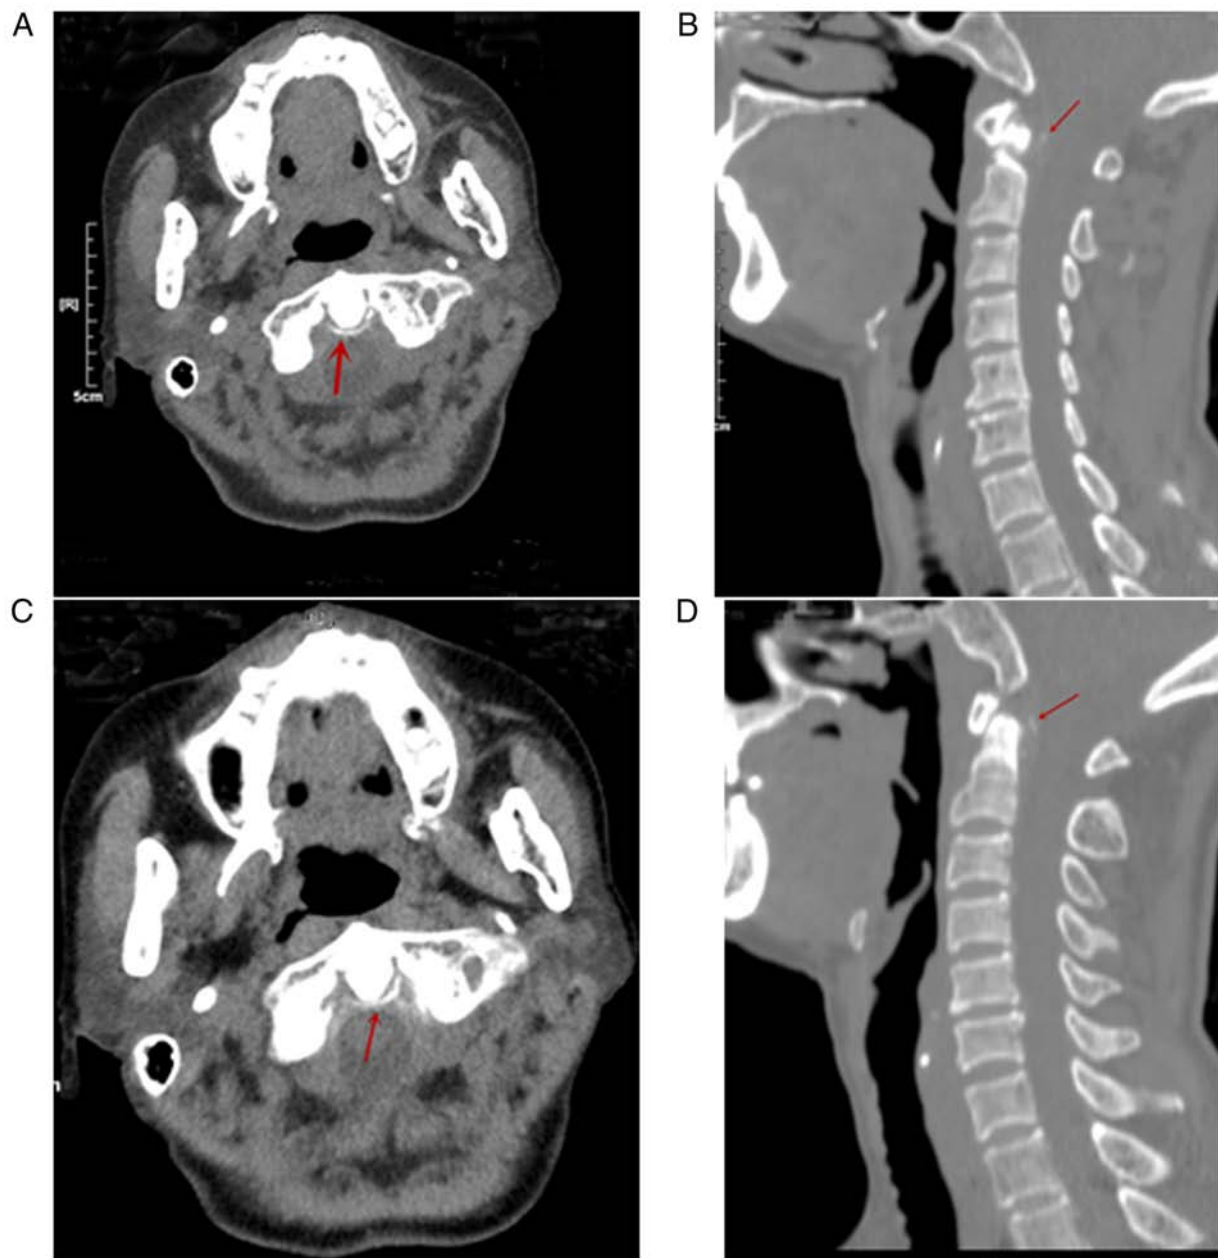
CT scans of a 76-year-old female. (A and B) CT scans at baseline revealing (A) an arc-shaped calcification of the transverse ligament and (B) vertical line-like calcification of the cruciate ligament of the atlas in the posterior area of the odontoid process. (C and D) Follow-up CT images at 10 months display (C) the arc-shaped calcification of the transverse ligament and (D) vertical line-like calcification of the cruciate ligament of the atlas in the posterior area of the odontoid process. Red arrows indicate the sites of calcium deposition.
